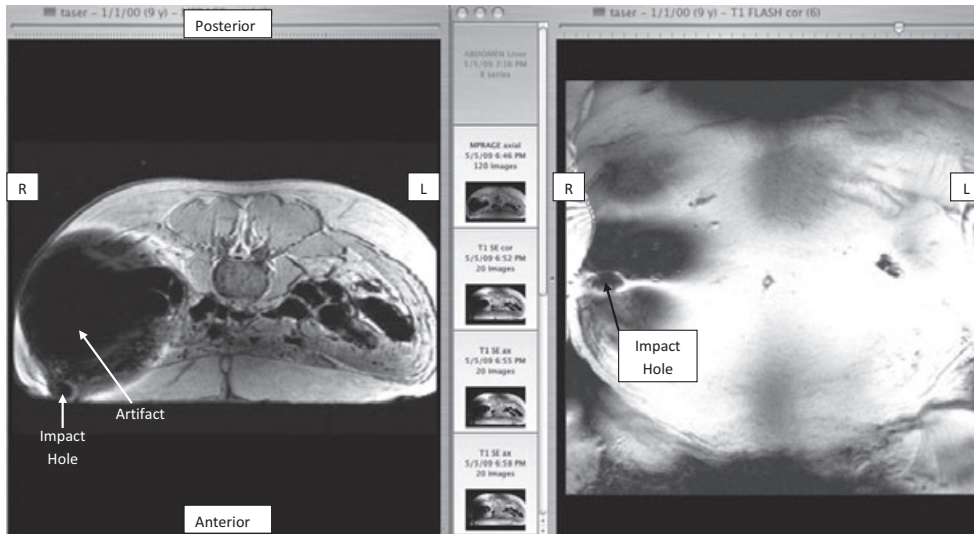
Posttest MR image of Torso 2 at the skin surface showing the penetration from shot 2Q1. Left: axial, Right: coronal.
